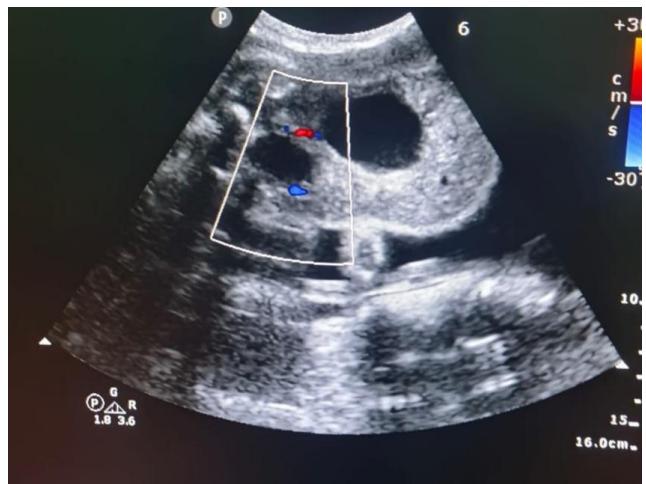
Obstetric ultrasound image showing fetal ovarian cyst measuring 4 x 4 cm
